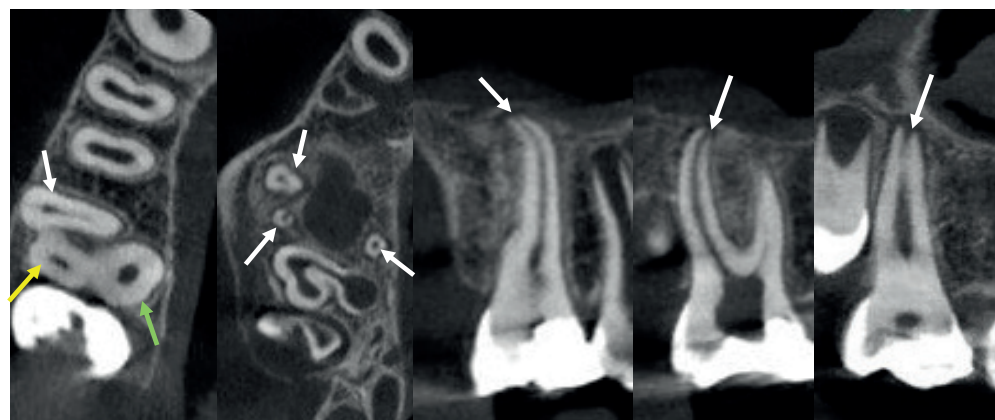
High resolution CBCT images of the right, maxillary first molar depicting the preoperative root canal anatomy: (a) Axial view at the level of the coronal third of the roots showing a very oval shaped mesiobuccal root (white arrow) and round distobuccal (green arrow) and palatal (yellow arrow) roots with patent root canal systems; (b) Axial view at level 0.5-1mm from the apex of the roots showing mesiobuccal, distobuccal and palatal roots with two immature apices (white arrows); (c) Coronal view of the mesiobuccal root canal system ending in an open apex (arrow); (d) Coronal view of the distobuccal root canal system ending in an open apex (arrow); (e) Coronal view of the palatal root canal system ending in an open apex (arrow). Note that all three root canal systems are patent without any calcifications present.
